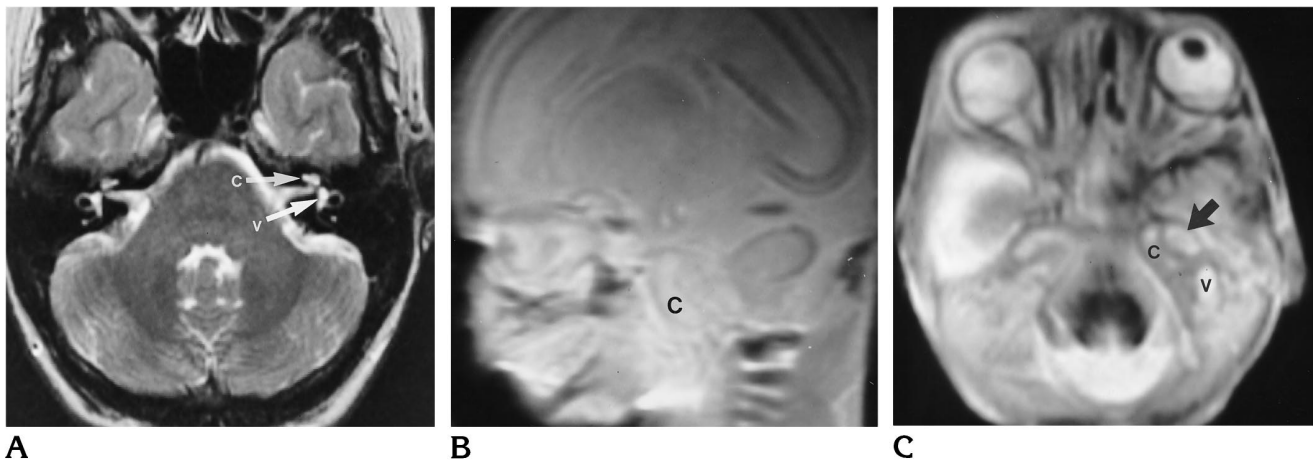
Comparison of adult and early fetal otic capsule structures on T2-weighted fast spin-echo MR images.
